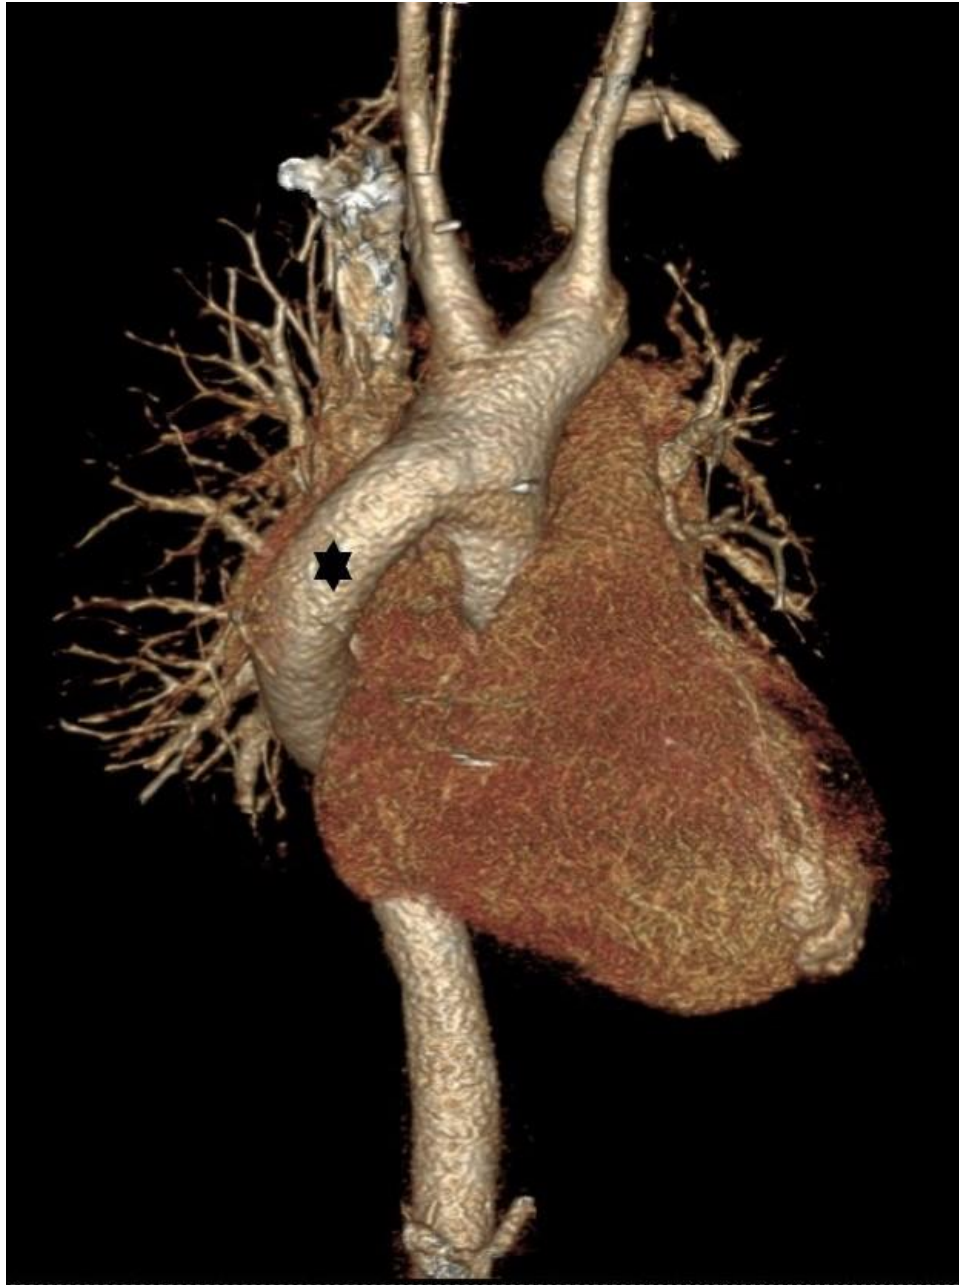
The 3D computed tomography image of the patient after the second operation shows the Dacron graft extension on the right side of the heart from the distal portion of the ascending aorta to the descending aorta (black mark).
